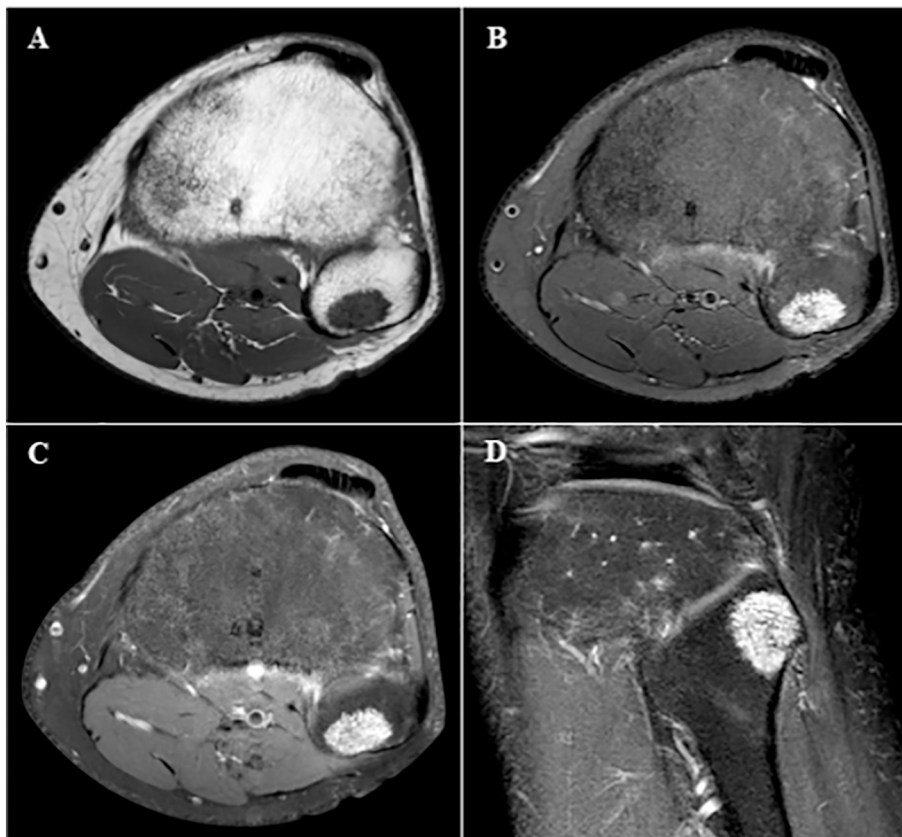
Pre-operative left fibular MRI scan
